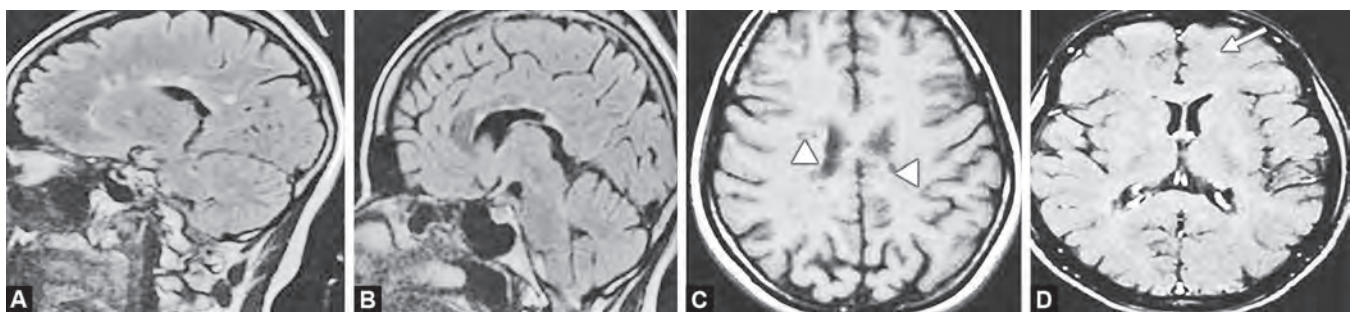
(A, B) Sagittal FLAIR image shows multiple hyperintense round/ovoid lesions that radiate from the lateral ventricles known as "Dawson's fingers" and a triangular shaped plaque with alternating linear hyperintensity in the ependyma known as "Ependymal dot dash sign". (C) T1WI showing black holes (arrowheads). (D) The T1 post-contrast image shows a subtle enhancing lesion (arrow) in the left frontal lobe, suggesting an active demyelinating plaque
